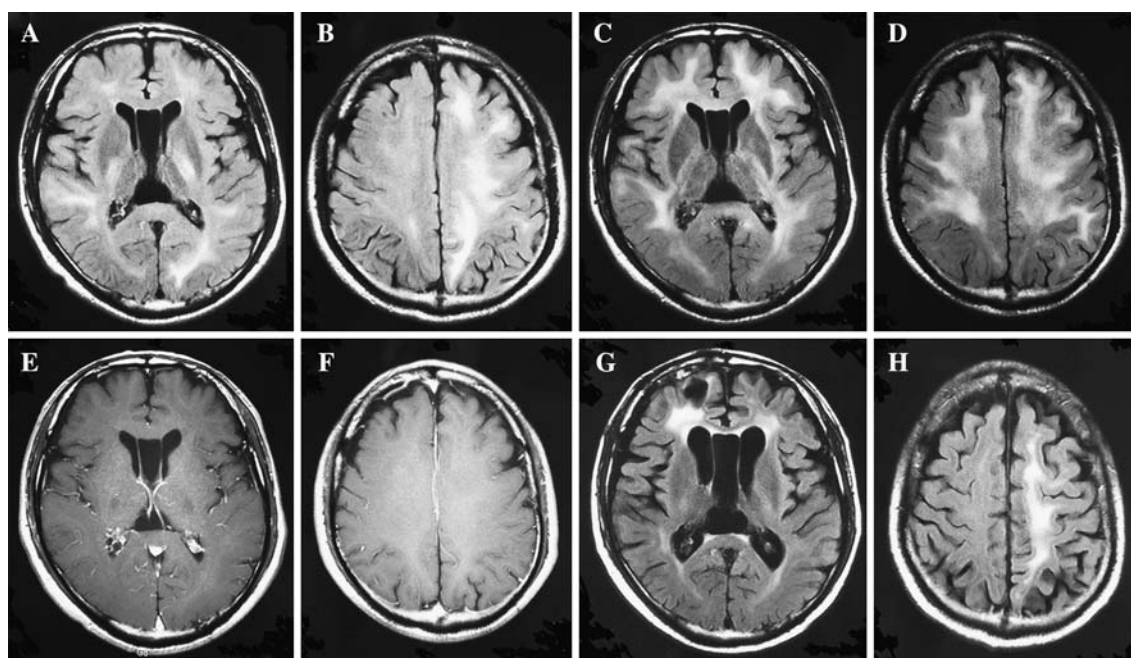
(A, B) Cerebral MRI at initial presentation, FLAIR-weighted images showing pathological signal hyperintensities in the white matter of both hemispheres. Those lesions were accentuated in the left side. (C–F) MRI at admission (4 months from initial presentation). C/ D: FLAIR-weighted images at corresponding planes to A/B. Compared with the first MRI (A/B), white matter lesions markedly progressed, and appear almost symmetric. Note that those lesions now
